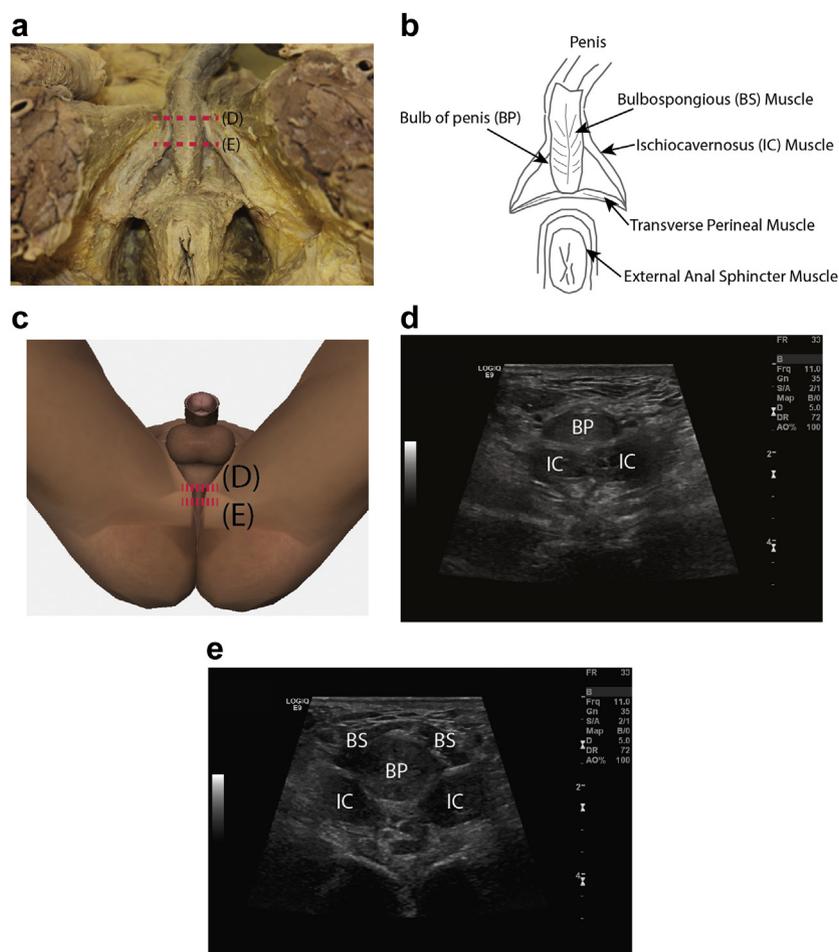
Cadaver dissection of the superficial male pelvis (a) with superficial structures of interest identified (b) and structural correlates on transverse sonographic images indicated by the red dashed lines (c) at one quarter (d) and one half (e) the anteroposterior length of the perineum.
